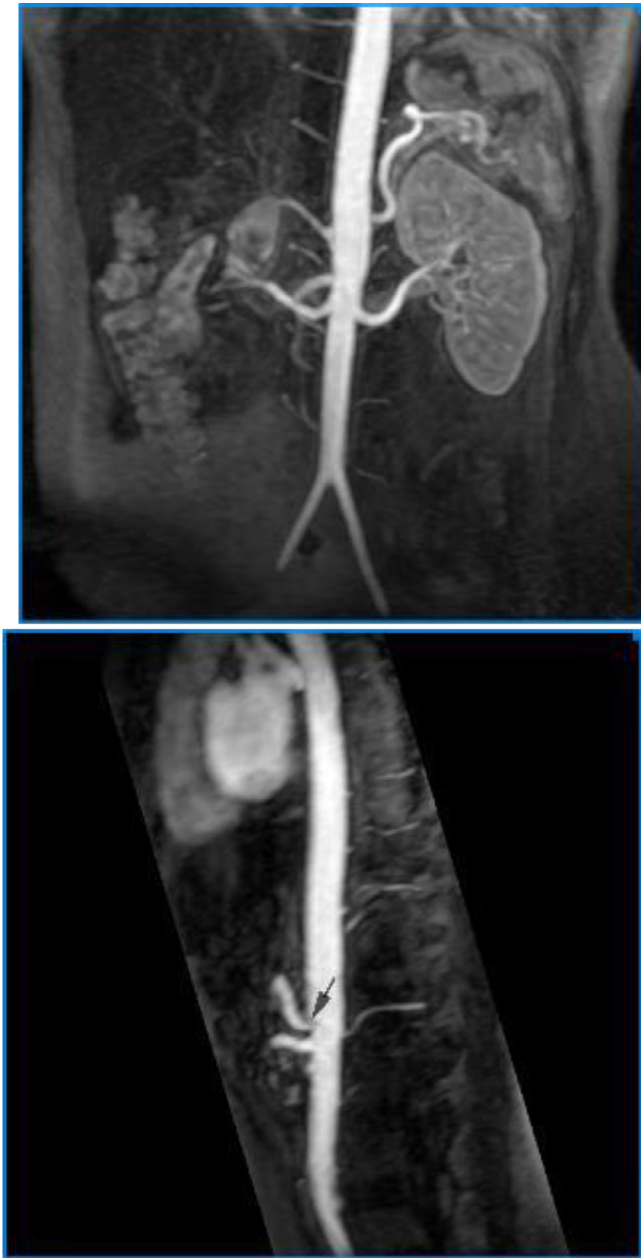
Angio MRI of abdominal aorta and renal arteries don't seem to be affected much, except for a mild narrowing at the origin of the celiac artery (black arrow).
